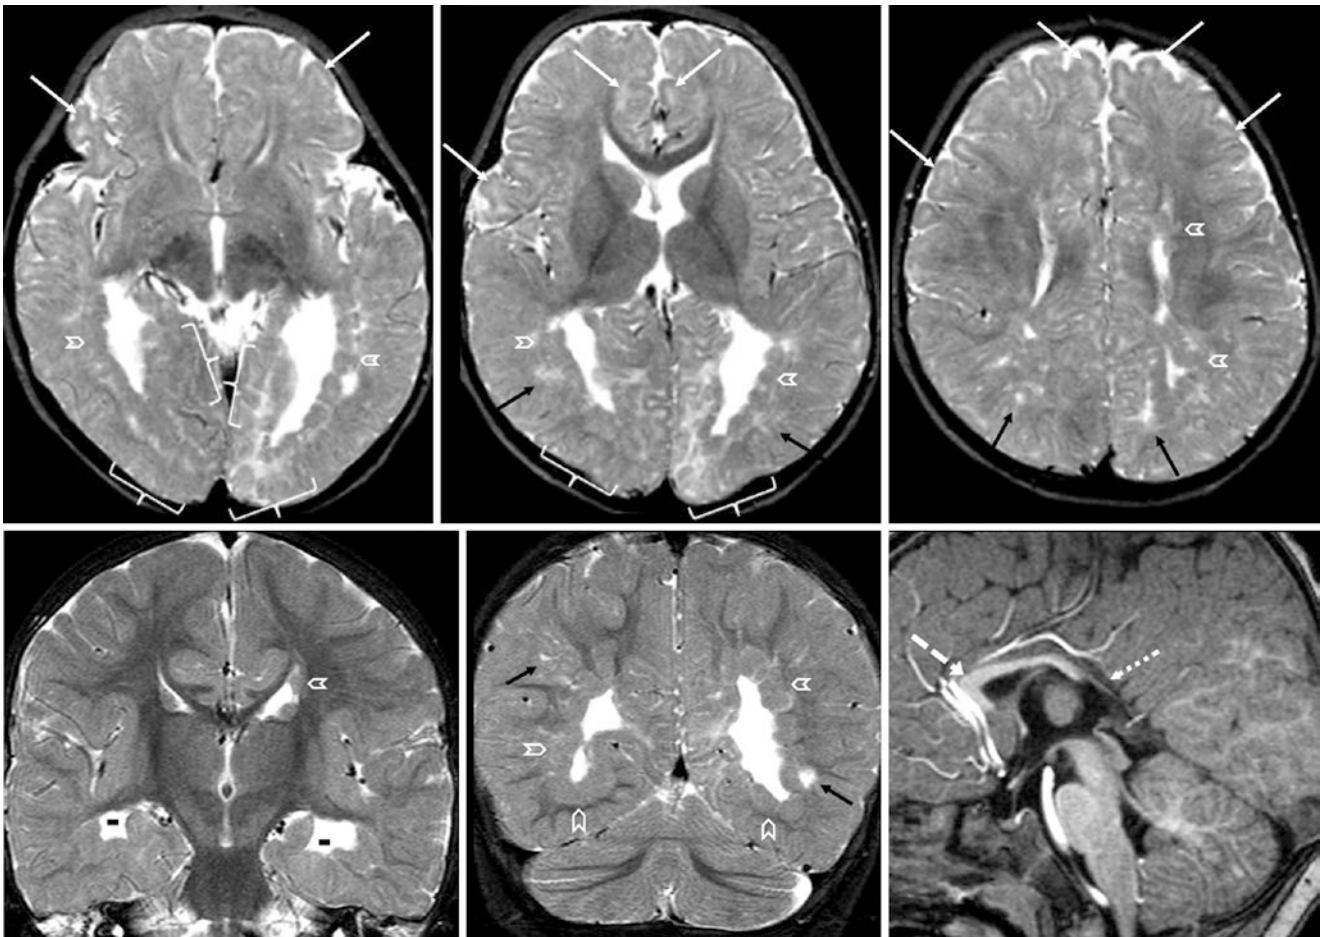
Comparison case of diffuse periventricular nodular heterotopia (PVNH) and polymicrogyria (PMG). A 12-month-old had diffuse PVNH (examples shown by chevrons), on a 3T MRI with axial (top row) and coronal (bottom left and middle) SE T2WIs. The PVNH is more prominent posteriorly, likely with bilateral medial occipital
